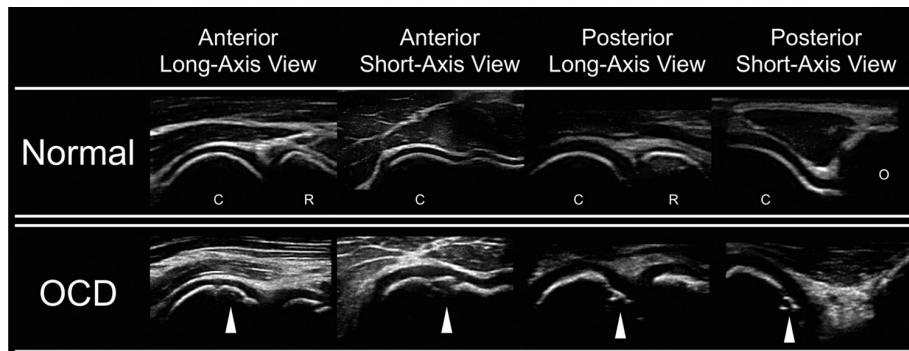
Ultrasonographic images of the humeral capitellum (normal and OCD). (Top row) In the normal capitellum, the echo lines of the subchondral bone are smooth. (Bottom row) Images of a capitellum affected by OCD show an irregularity, a break in continuity of the echo line, and a double floor line of the subchondral bone of the capitellum (white arrowheads). C, capitellum; O, olecranon; OCD, osteochondritis dissecans; R, radial head.
